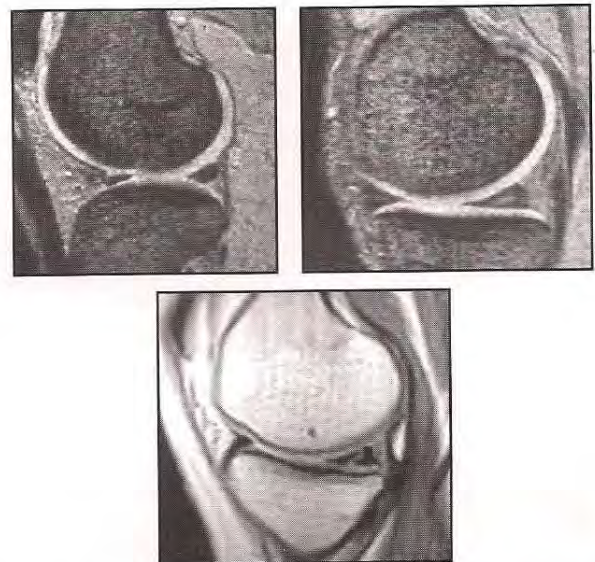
Grading scale for meniscal tears on MRI. Grade 0 is a normal meniscus. Grades I and II have an intrameniscal signal that does not abut the free edge. Grade III has a signal change that abuts the free edge of the meniscus, indicating a meniscal tear.
